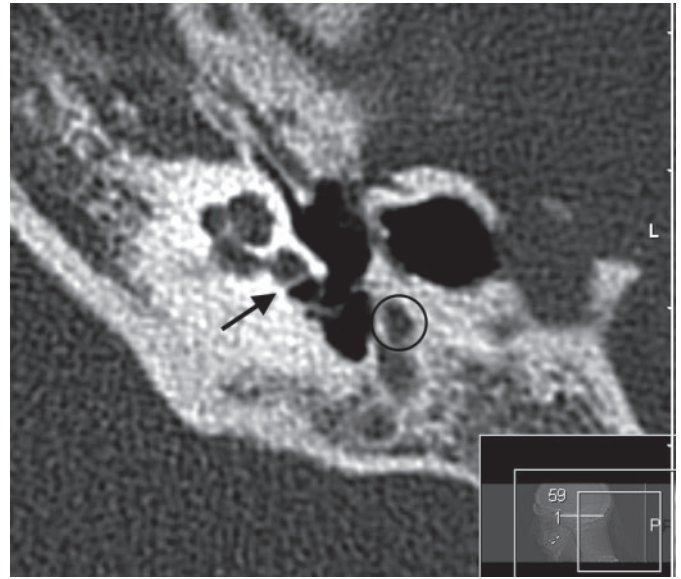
Preoperative CT scan, showing the intact round window (arrow) and the facial nerve (circle).
